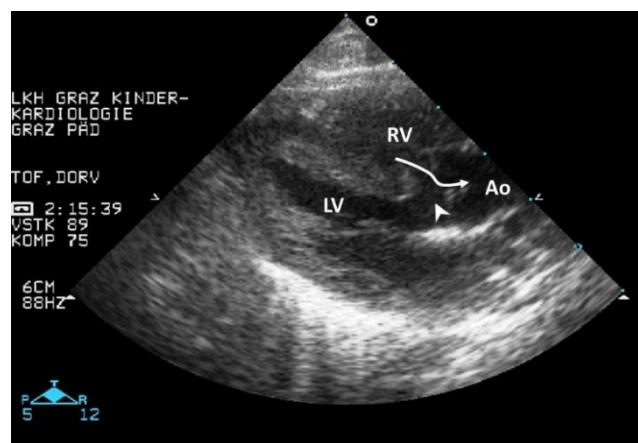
2-d echocardiography of a patient with uncorrected Tetralogy of Fallot (parasternal long axis): Ventricular septum defect (◄) with aortic overriding. Abbreviations: Ao (aorta); LV (left ventricle); RV (right ventricle). *Division of Paediatric Cardiology, Department of Children and Adolescent Medicine, Medical University Graz*
